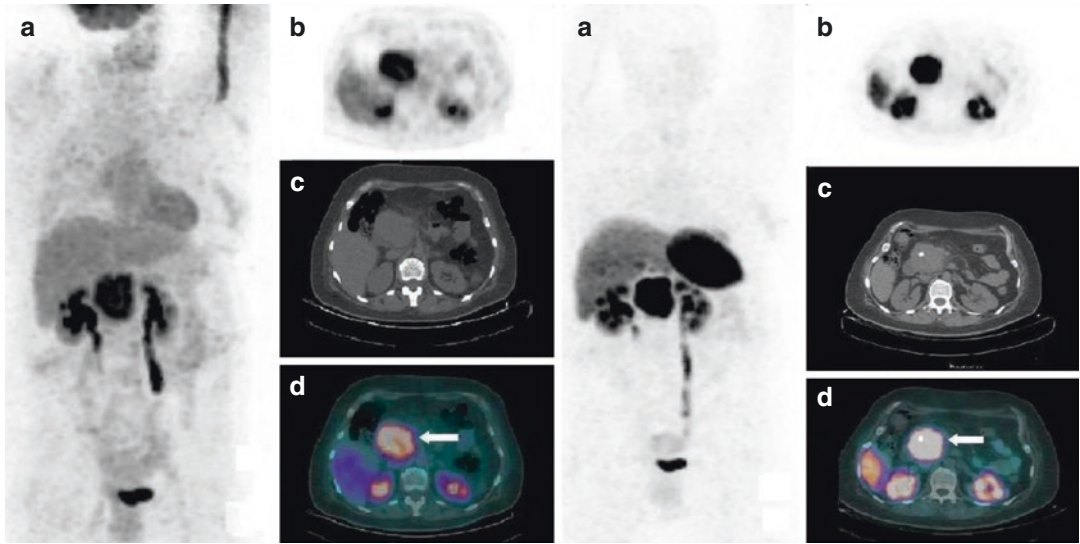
Patient with occasional finding of a gross pancreatic mass during an US examination of the abdomen. (a) CT scan demonstrated a pancreatic mass (transverse diameter = 6 cm) containing areas of necrosis and calcifications. Patient was submitted to endoscopic ultrasonography (US)-guided fine-needle aspiration biopsy (FNAB). Cytology resulted positive for adenocarcinoma. ¹⁸F-FDG PET/CT MIP (a) and fused transaxial images (d, arrow)
